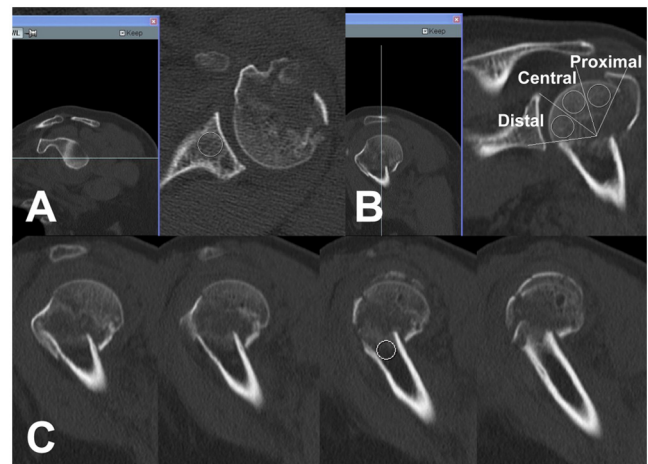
Image selection on the sagittal or coronal plane of a shoulder computed tomography scan. The image used for measurement of the region of interest measurement took place on the axial (A, glenoid) or coronal (B, humeral head) plane was selected by using dynamic scout navigation to choose the central portion of each bony region in the sagittal plane. A circular region of interest was placed on the center of the metaphysis on coronal plane to assess bone attenuation of humeral metaphysis (C).
